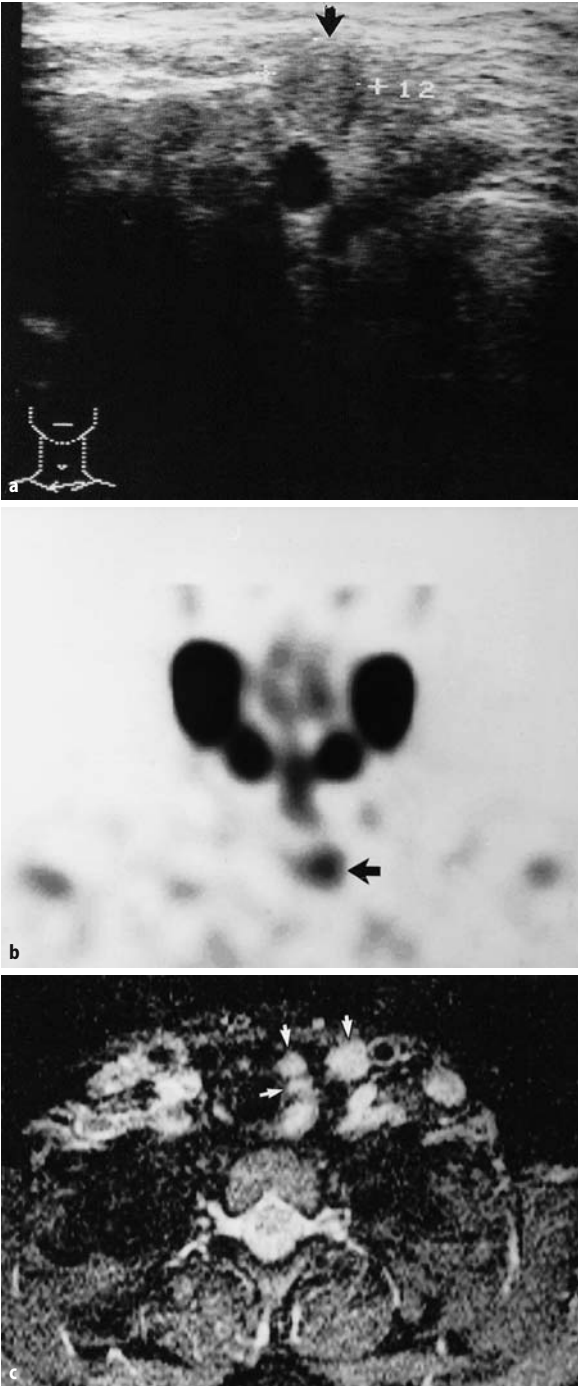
Follow-up of a papillary thyroid cancer patient with the last RIT 1 year ago. The RI scan was negative, but sonography showed a hypoechoic lesion with a diameter of 12 mm near to the left carotid artery (a). A ^{99m}Tc -sestamibi scan was positive (b; coronal SPECT). The MRI demonstrated three lesions between the trachea and the left carotid artery (arrows) and some additional small lesions in the right paratracheal space (c, STIR; d, T2 TSE-weighted sequence; e, T1-weighted sequence). The greater lesions on the left side showed significant post-Gd contrast enhancement (f)
